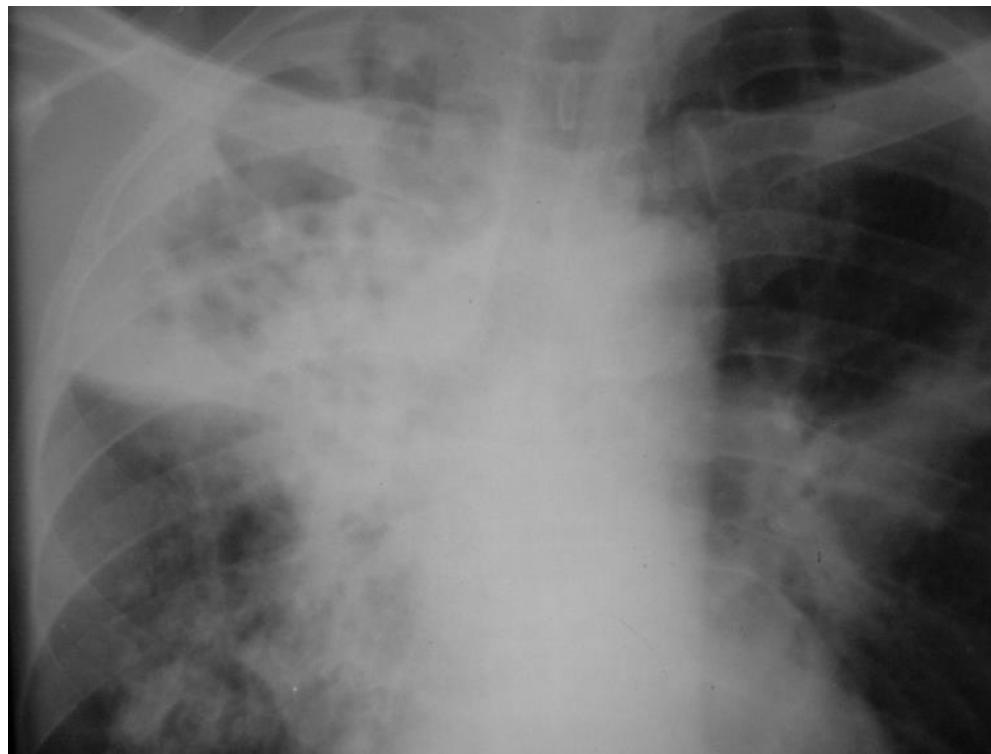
Chest radiograph in pulmonary tuberculosis showing right upper lobe fibrocystic changes, consolidation and a cavity in the right apex.
